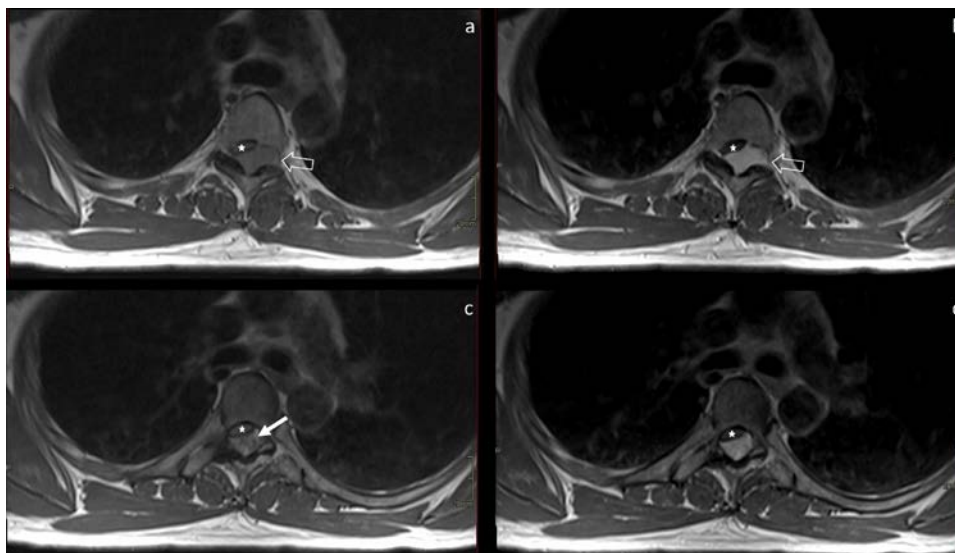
Axial T1-weighted pre-contrast (a, c) and corresponding post-contrast (b, d) images at the levels of the T4-T5 intervertebral foramen and the T5 vertebral body. Images obtained at the same levels as the previous figure demonstrate the extradural lesion, located posterolaterally. As previously noted, there is compression of the neural elements with anteromedial displacement of the spinal cord (star). Extension through the intervertebral foramen is visible (seen on a, b - open arrow). Multiple serpentine flow voids are identified within the lesion (seen on c - arrow). No infiltrative features, bony erosion, or remodelling are observed.
